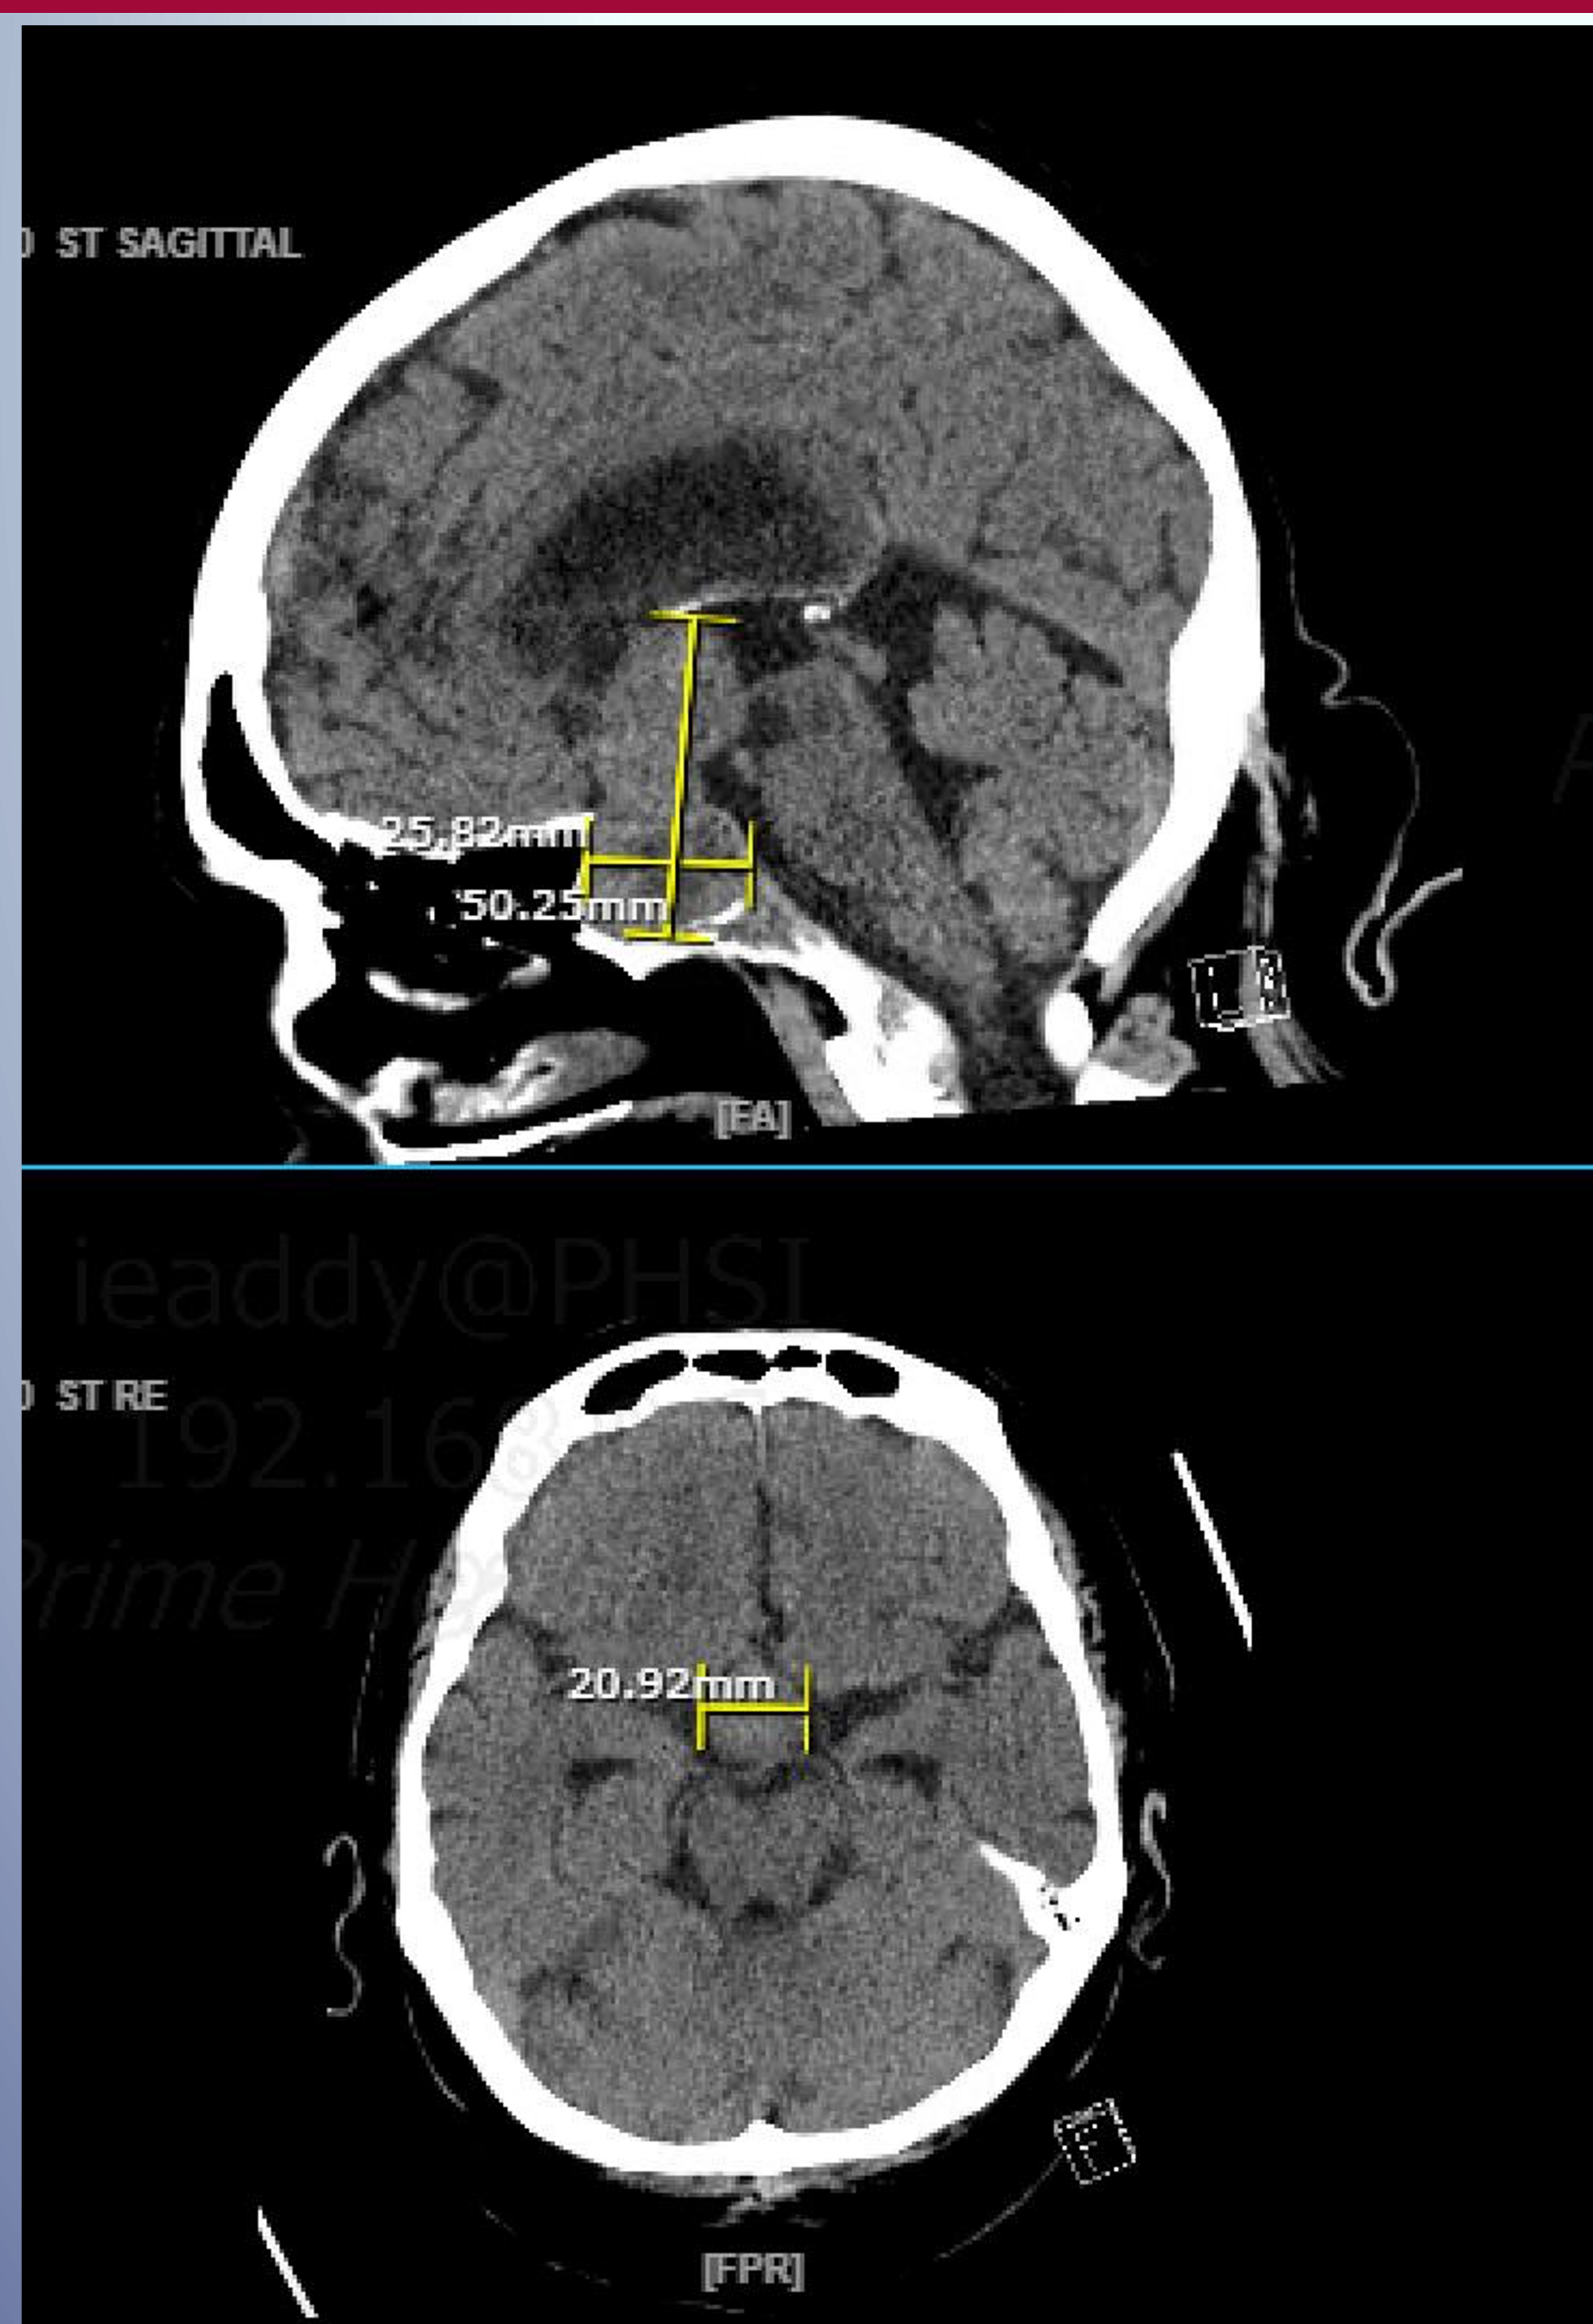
A 2.1 x 5.0 x 2.6 cm macroadenoma imaged on CT head without contrast, seen in sagittal (A.) and transverse (B.) views.
